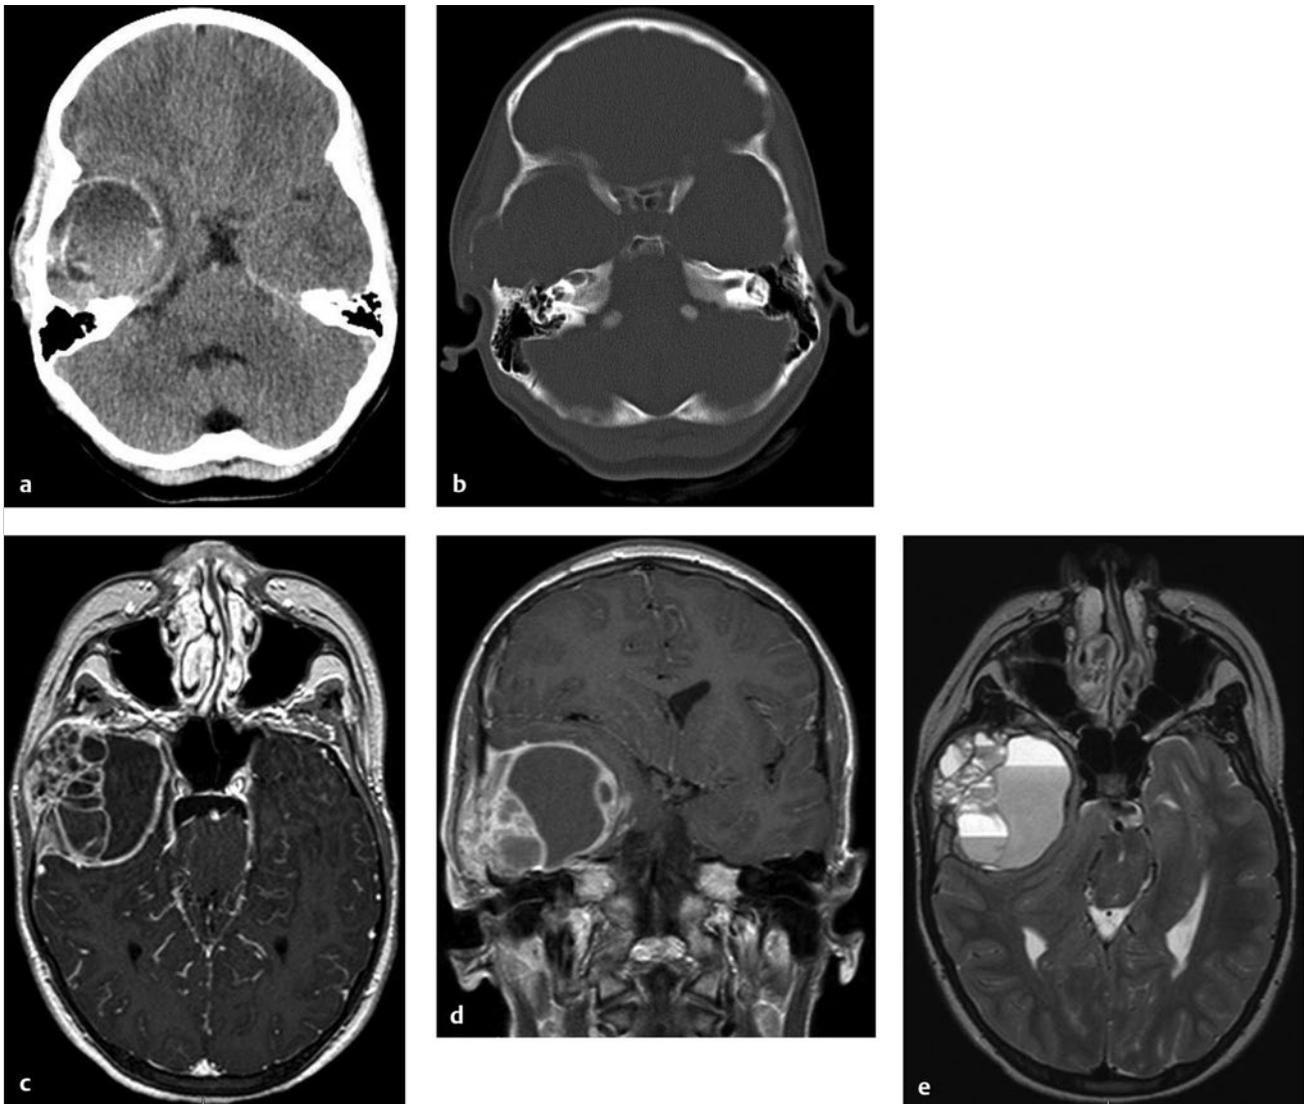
Aneurysmal bone cyst. This 12-year-old girl presented with a nontender firm mass in the right temple. (a,b) Computed tomography shows calcification surrounding the lesion; bone windows show a thin shell of intact bone externally. (c,d) Axial and coronal T1-weighted images with contrast reveal an enhancing soft tissue portion of the tumor. (e) Axial T2-weighted image shows typical fluid–fluid levels of nonclotted blood.
